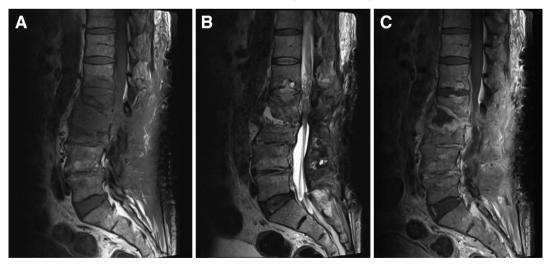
Lumbar magnetic resonance imaging (MRI) before treatment. T1-weighted (A), T2-weighted (B), and contrast-enhanced T1-weighted (C) MRI images showed. Findings compatible with spondylodiscitis in intervertebral disc and discovertebral joint at the L2-3 vertebral level that was hypointense in T1-weighted, hyperintense in T2-weighted cross-sections, and had heterogeneous contrast enhancement in contrast-enhanced T1-weighted images. Intradiscal abscess formation with peripheral contrast enhancement was also detected in the intradiscal space. Contrast enhancement and thickening of the anterior epidural soft tissue consistent with phlegmon were detected at the L1, L2, and L3 vertebra levels, as well as contrast enhancement in the anterior paravertebral soft tissue and paraspinal muscles consistent with inflammation
